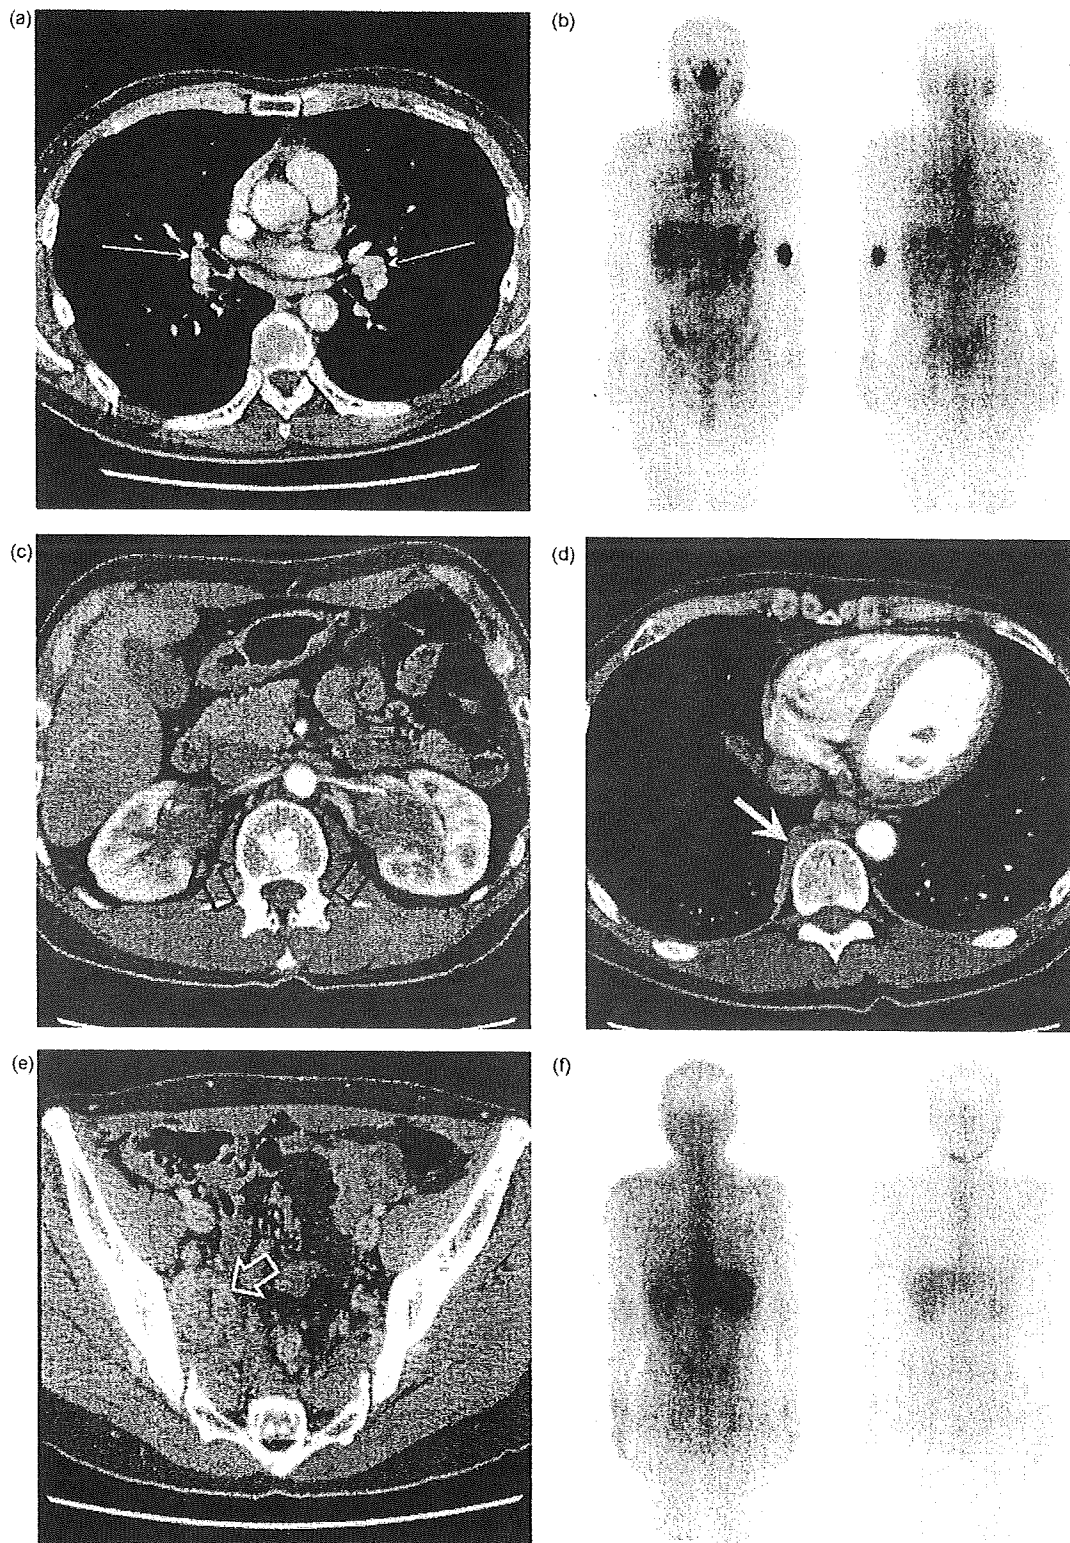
Hilar lymphadenopathy in a 50-year-old man. (a) Dynamic contrast-enhanced CT shows hilar lymphadenopathy (long arrows). (b) Ga-67 scintigraphy demonstrates an increased uptake in right parotid gland and right retroperitoneum, as well as hilum. (c-e) Another slice of the dynamic contrast-enhanced CT identifies bilateral renal lesions (open arrows in c), paravertebral mass (white arrow in d) and retroperitoneal lesion (white open arrow in e) (to be describe). (f) After corticosteroid therapy, the accumulation of Ga-67 disappeared in each lesion.
